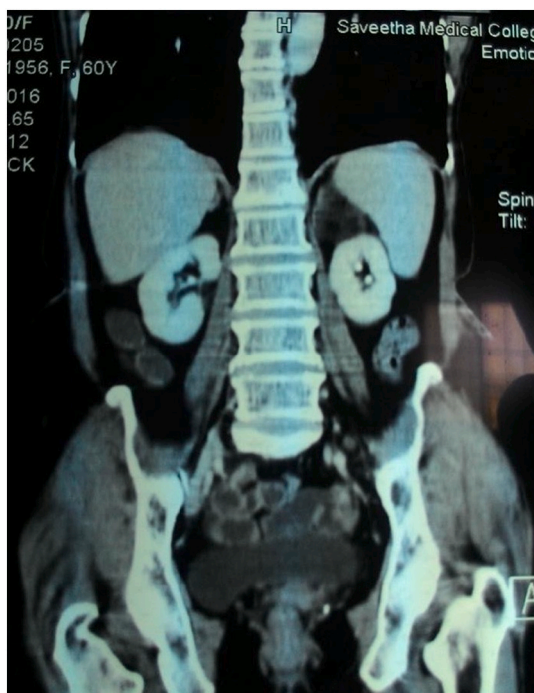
Contrast enhanced CT film of the adrenal mass.
